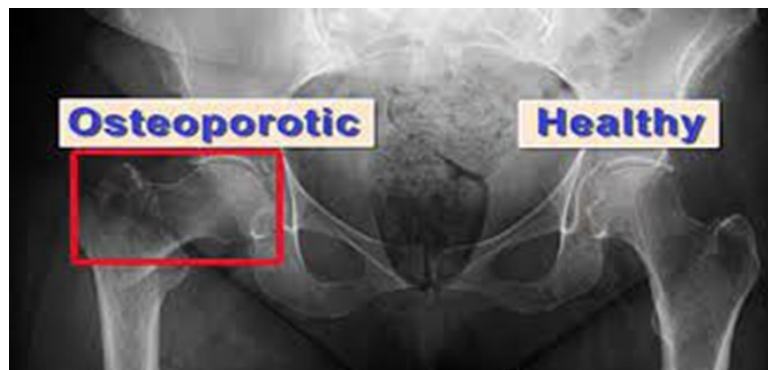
Plain X-ray of hip demonstrate healthy and osteoporotic bone
